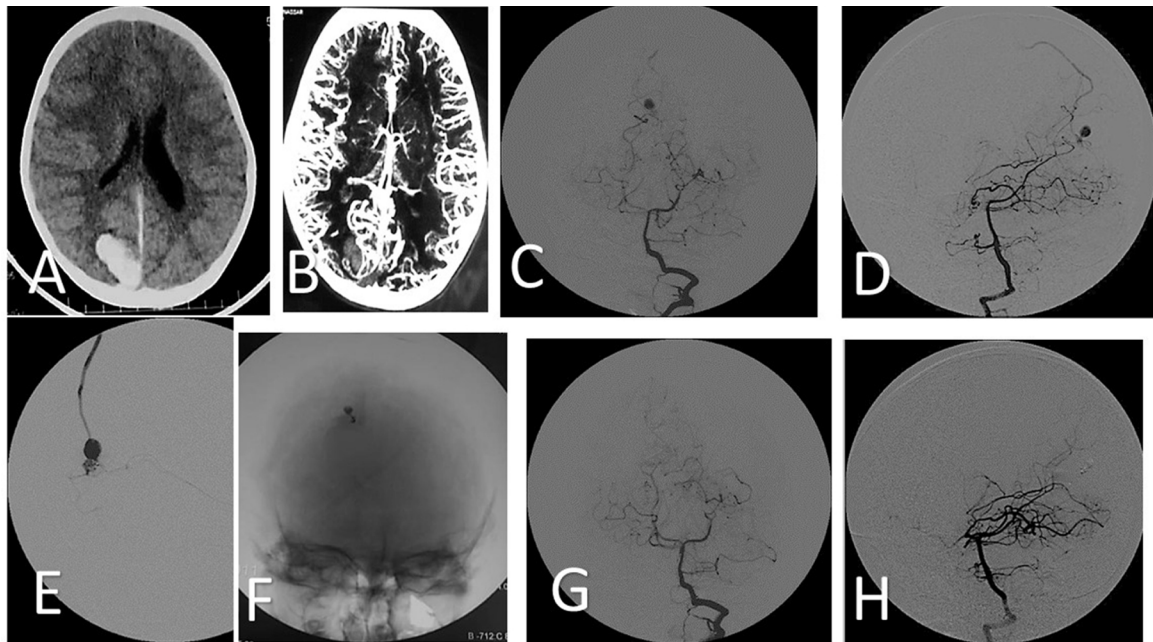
Female child, 7 years old, presented with right occipital ICH. CTA shows small occipital AVM with nidal aneurysm. Endovascular embolization performed in one session with total obliteration of AVM & nidal aneurysm. (A) Axial CT brain shows ICH (B) CTA shows right occipital small AVM and ICH (C&D) Left vertebral angiogram shows small occipital AVM & nidal aneurysm (E) Super selective catheterization of the feeding artery (F) Fluoroscopic image shows glue cast in nidus and aneurysm (G&H) Control left vertebral angiogram shows total obliteration of both AVM and nidal aneurysm.
